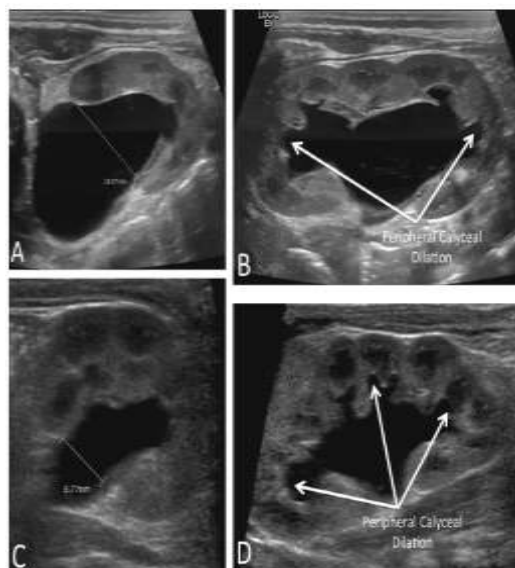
Appearance of UTD P2 on postnatal ultrasound. A: Imaging in the transverse plane demonstrates an anterior-posterior renal pelvis diameter (APRPD) ≥ 15 mm. B: Imaging in the sagittal plane demonstrates peripheral calyceal dilation but normal renal parenchymal thickness and appearance. In addition, there are no bladder abnormalities (not shown). Another example of UTD P2 on postnatal US. C: Imaging in the transverse plane demonstrates an APRPD <10 mm. D: However, imaging in the sagittal plane demonstrates peripheral and central calyceal dilation.
